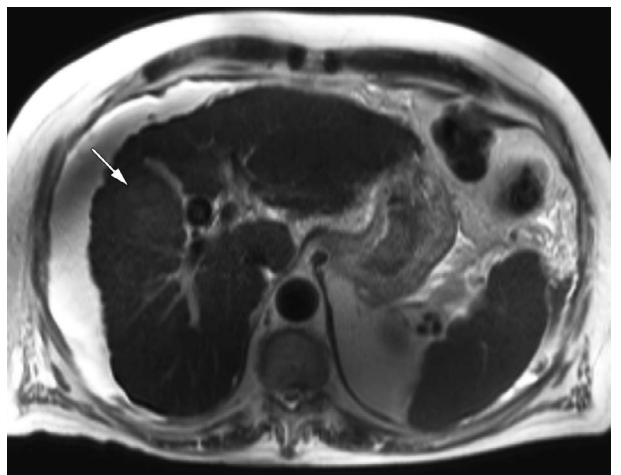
HCC. Annotated. Liver. MRI. T2 weighted. Single shot. Axial plane. An arrow points to a focal lesion in the right hepatic lobe. The tumor is not very conspicuous on T2-weighted imaging, with only mildly increased signal.
